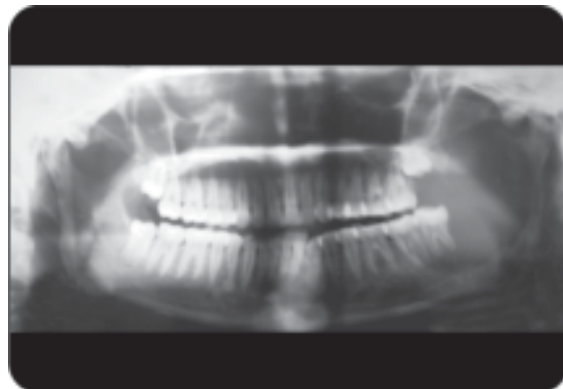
X-ray of neurogenic sarcoma-I
